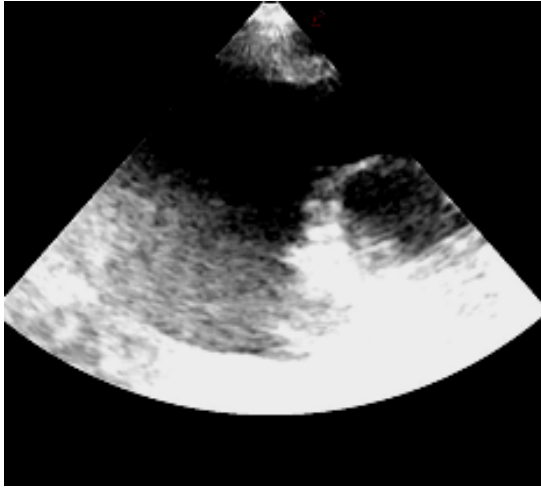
Ultrasonography-Pleural effusion
